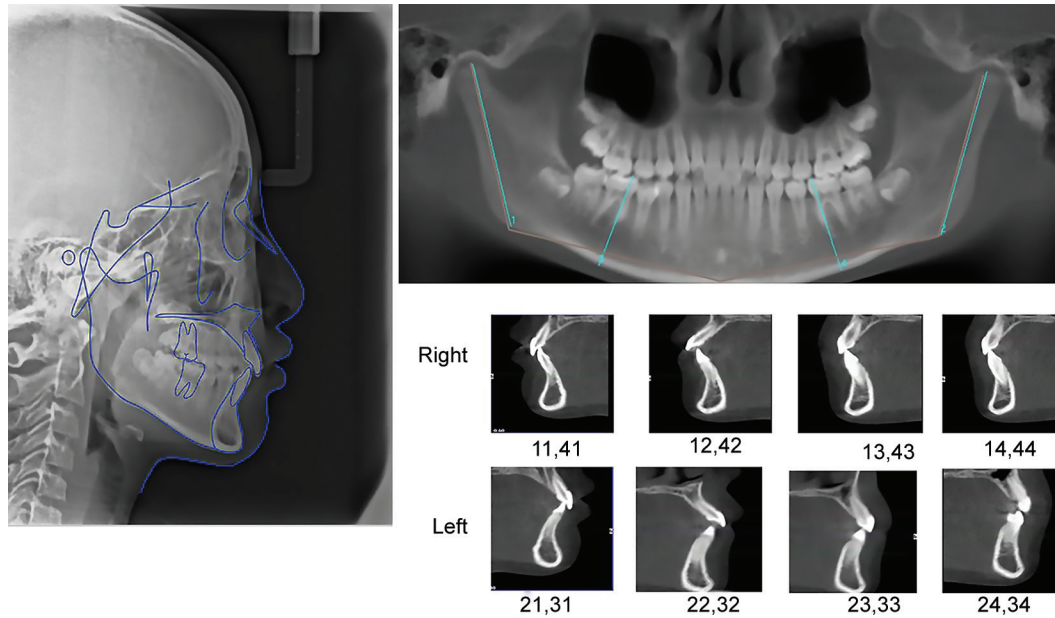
Pretreatment lateral cephalogram and panoramic radiographs
